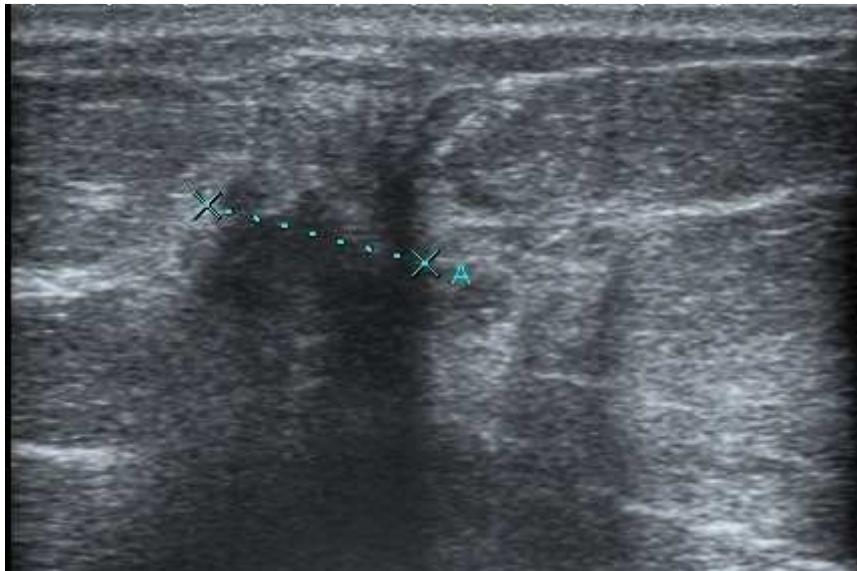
breast carcinoma on US and MRI
